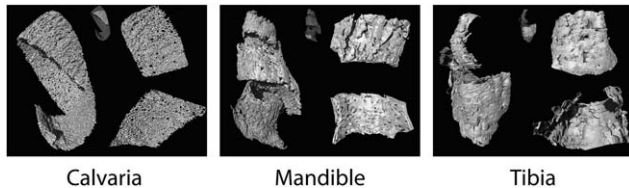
Micro computed tomography of 3 preparations of bone chips. Bone chips from calvaria, mandible, and tibia were scanned by micro computed tomography at an isotropic resolution of 5 μm and visualized in Amira software. Data represent the results of 1 out of 2 independent preparations of bone chips.
